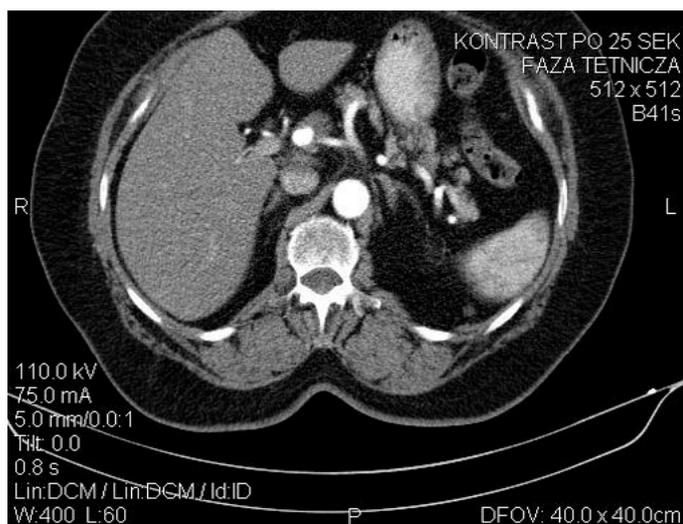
CT-scan of a 66-year-old female patient with hepatic artery pseudoaneurysm.
